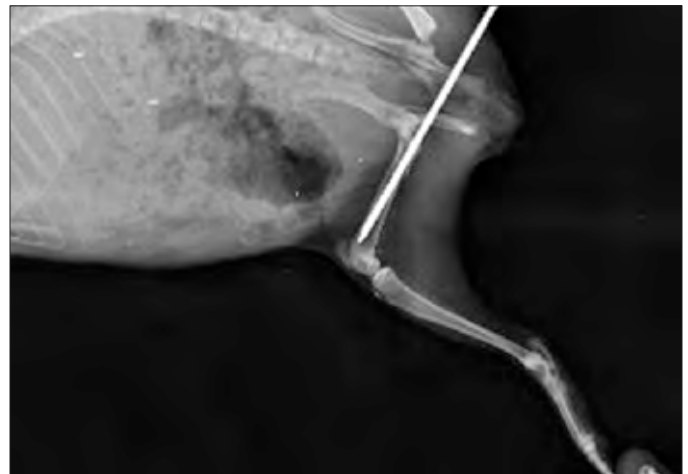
Immediate postoperative mediolateral radiograph showing proper reduction and apposition of fracture fragments.
